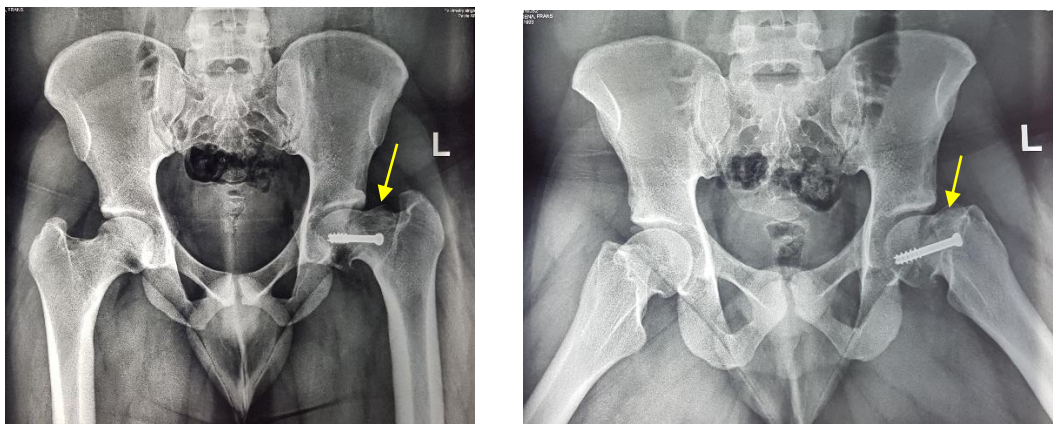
Pelvis and Frog leg lateral x-ray views showing FAI (arrow) of the left hip six years after *in situ* pinning.
